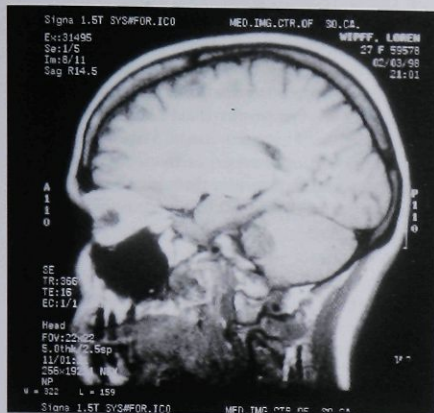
T1-weighted sagittal MRI showing 2.0-cm mass at the cerebellopontine angle.
